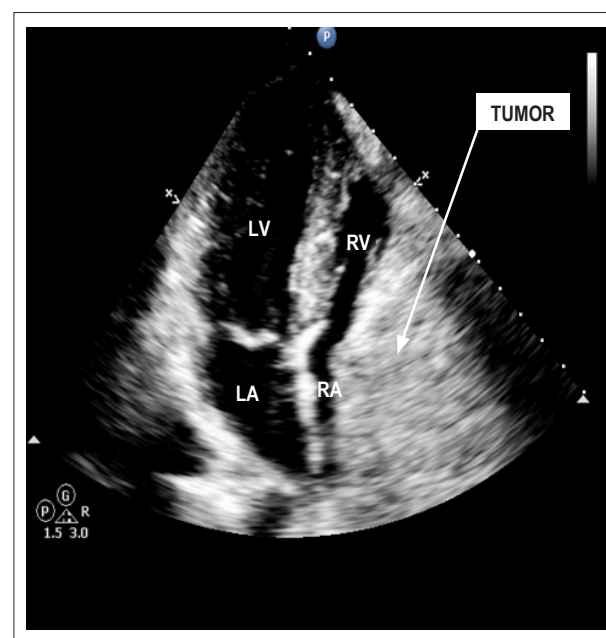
TTECHO (apical 4-chamber). LA: left atrium; RA: right atrium; LV: left ventricle; RV: right ventricle.
